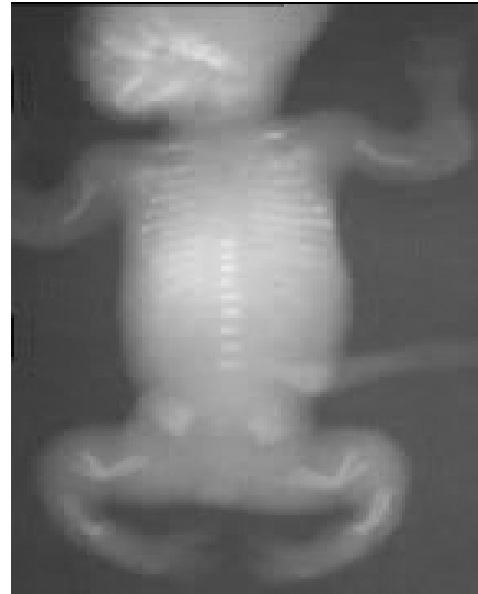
X-ray of aborted fetus
